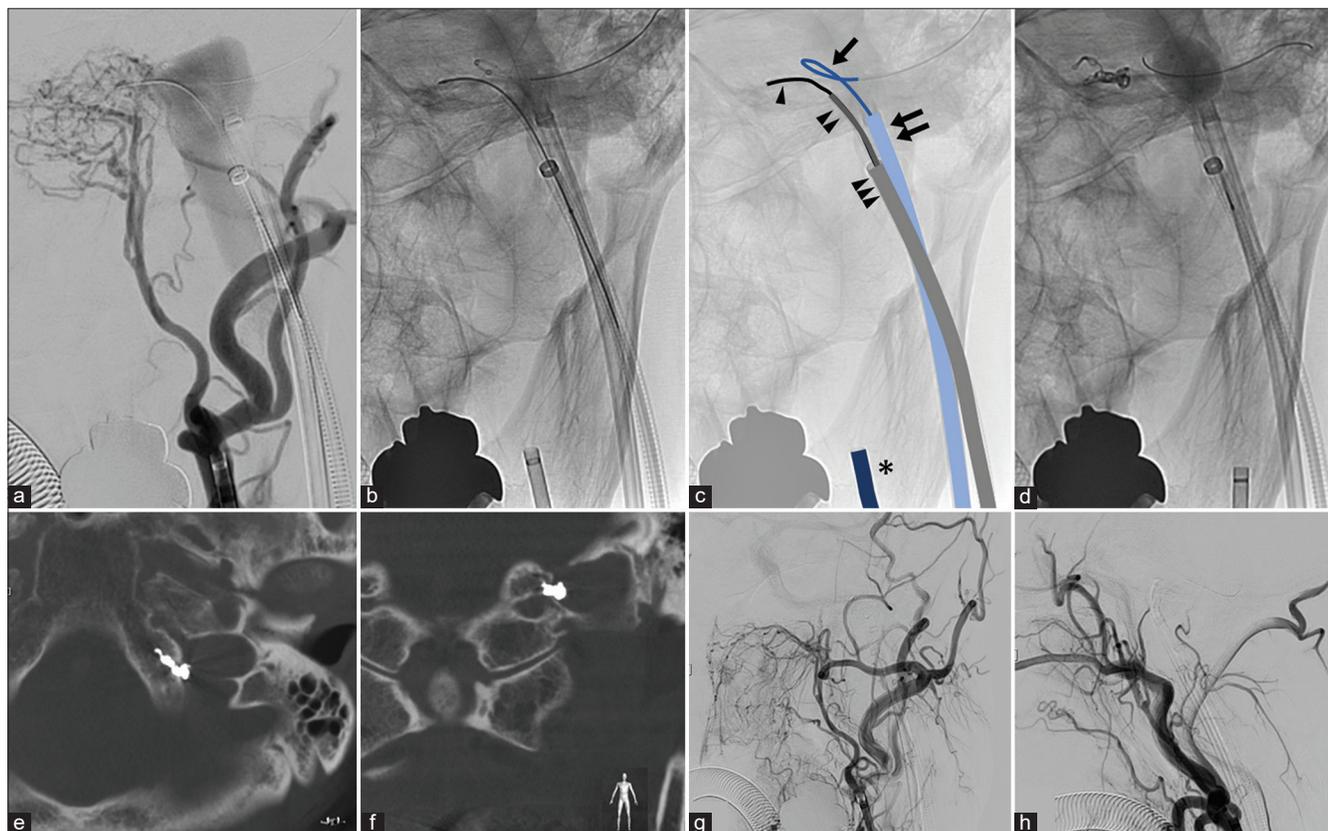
Endovascular treatment of dural arteriovenous fistula (a-d) and postoperative imaging (e-h) (a) Working angle view of the left external carotid angiography through a 4 Fr. guiding sheath (as seen in panel c: *) showing a dural arteriovenous fistula. (b and c) A microcatheter (single arrowhead) is guided to the shunt point using a 45° pre-shaped distal access catheter (double arrowhead) through a 6 Fr guiding sheath (triple arrowhead) which is placed in the left internal jugular vein. Another 6 Fr guiding sheath (double arrow) is also placed in the left internal jugular vein to guide a balloon catheter (single arrow) near the shunt. (d) The balloon catheter is inflated to support the microcatheter and to avoid deviation of the coil to the jugular vein. Coiling into the shunt pouch is performed through the catheter. (e and f) Axial and coronal view from cone-beam computed tomography images showing the detachable coils implanted in the shunt pouch within the bone. (g and h) Frontal and lateral view of the left external carotid angiography showing that the shunt is completely occluded.
